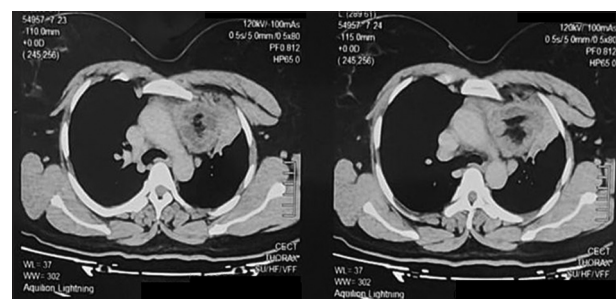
Computed tomography chest depicting an anterior mediastinal mass with internal fat density
